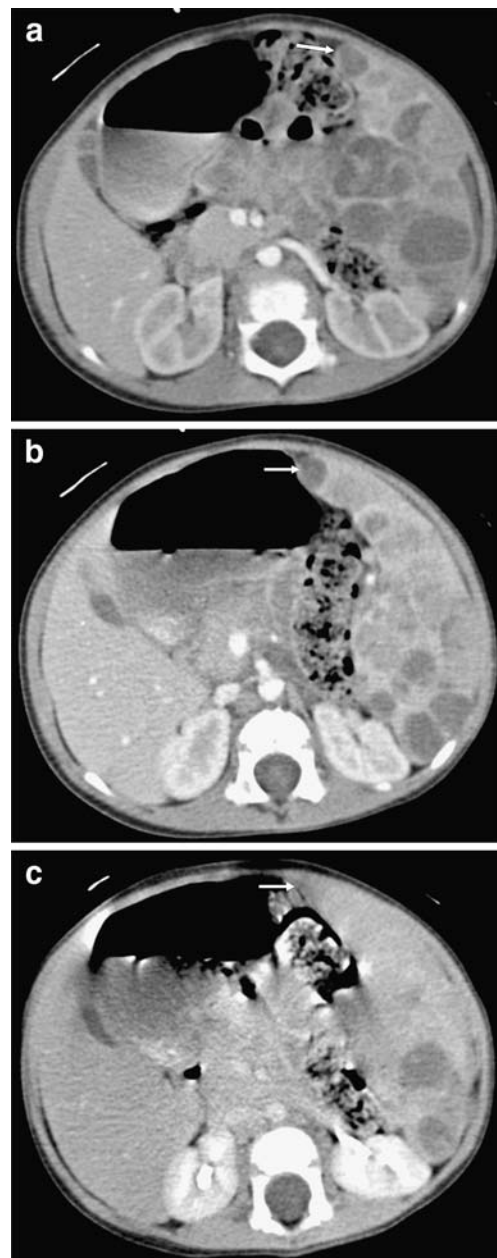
Axial CT images of the spleen show multiple round lesions of various sizes throughout the spleen. Gradual contrast enhancement of the lesions are nicely depicted (*arrows*) on the same cut of the spleen on the early arterial phase image (a), the early venous phase image (b), and the late venous phase image (c)
